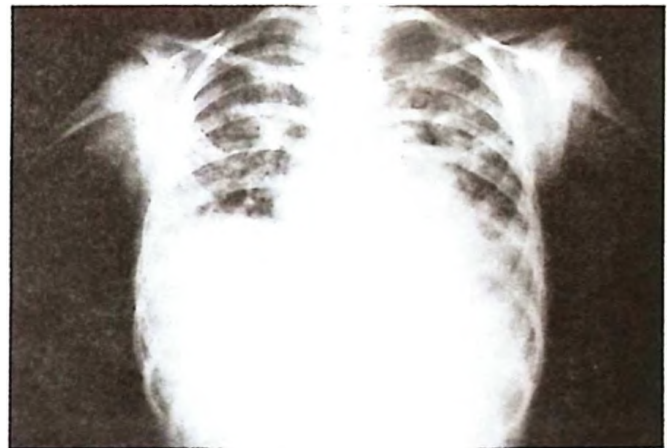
Chest roentgenogram showing fine but diffuse micronodular densities on the third hospital day.
